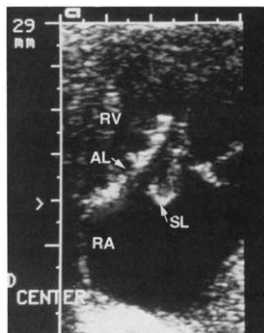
Case 22. Two-dimensional echocardiogram of tricuspid dysplasia initially diagnosed in a fetus at 20 weeks of gestation. The dysplastic-appearing tricuspid septal leaflet (SL) prolapses behind the thickened, redundant anterior leaflet (AL). RA = right atrium; RV = right ventricle.
